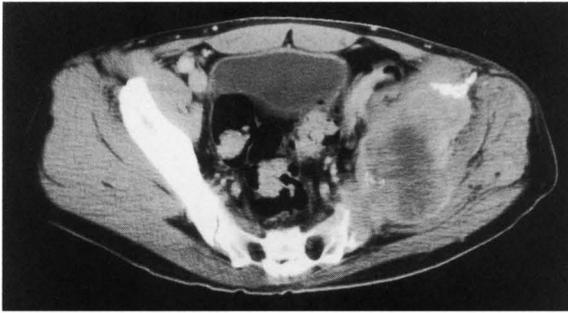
CT of the pelvis showed a massive bone metastasis ,which is from the left ilium (A) to the left acetabulum (B), and bone metastasis in the right ilium (C).
